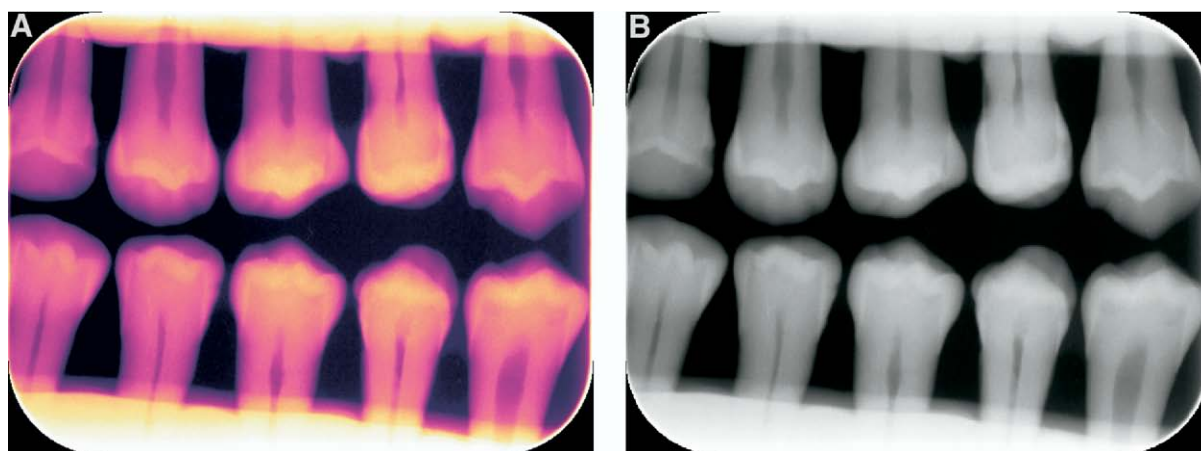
An example of a color-coded (A) and a black-and-white (B) radiograph employed for viewing.
